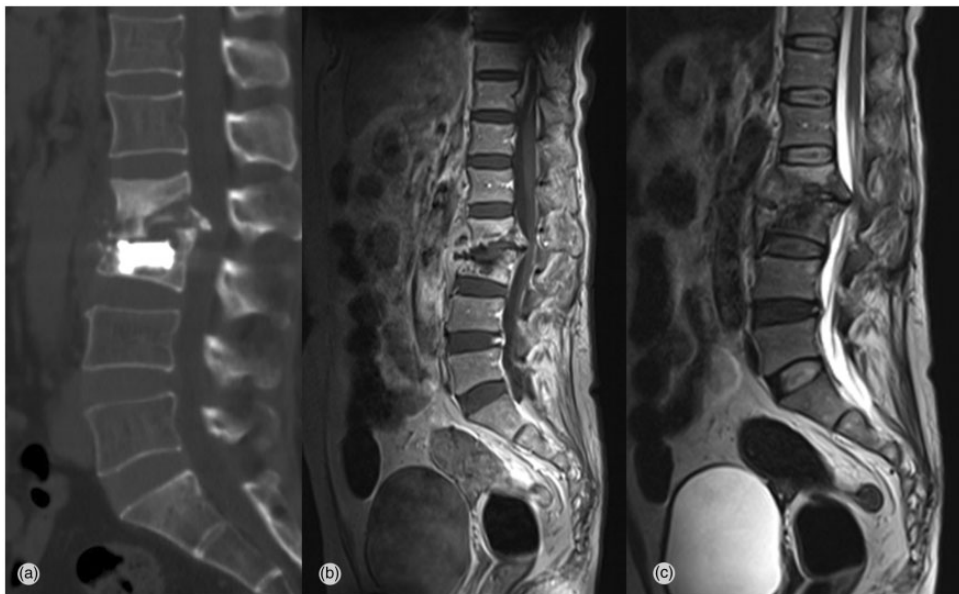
Approximately 10 months later, computed tomography and magnetic resonance imaging show severe spondylitis at the L2–L3 level, with paravertebral abscess formation and bony destruction of L2 and L3
